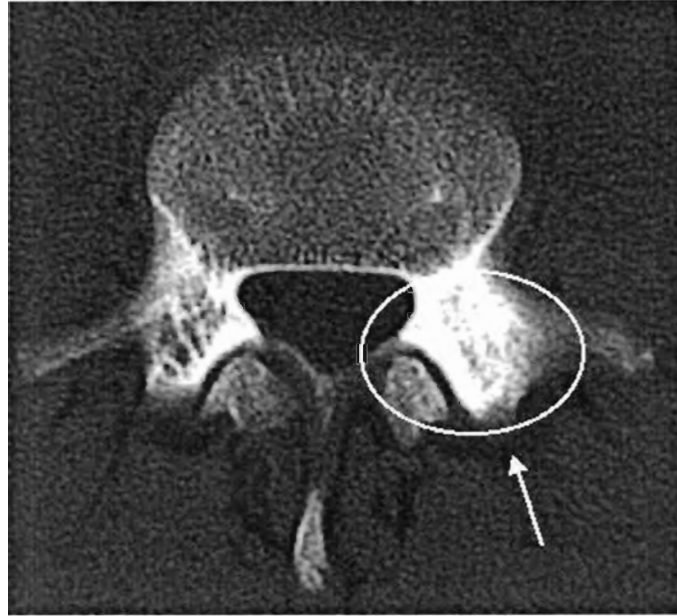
A CT scan of a 15-year-old right arm bowler (subject 6) taken at 3 months after the diagnosis of a stress fracture (isotope bone scan). This showed a thickening of the left pars interarticularis and left pedicle with no stress fracture.
